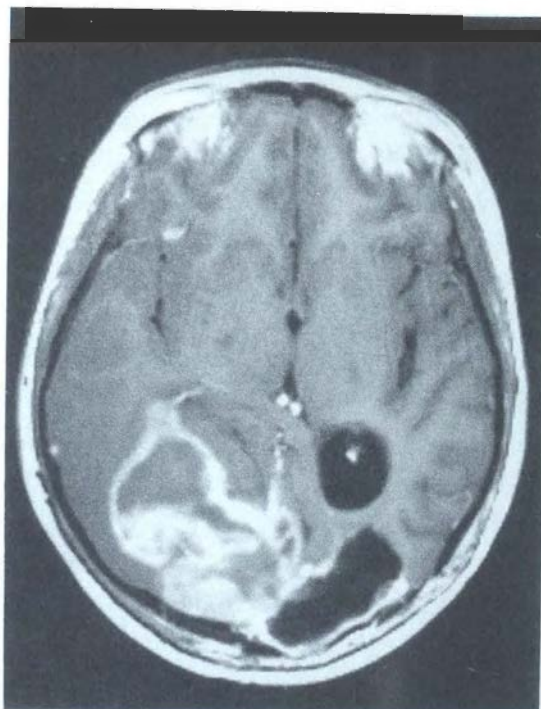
A large brain tumor showing heterogeneity of blood perfusion. A pediatric patient (11 years old), who had previously received surgery for glioblastoma multiforme, was examined for tumor recurrence 4 months after first surgery. This is a magnetic resonance image (MRI), obtained 10–20 minutes after injection of a contrast agent into the bloodstream. The region of brain from which tumor was previously excised is seen (lower right) as two dark cavities. The opposite cerebral hemisphere (lower left) has a very large invasive tumor originating from the earlier site of surgery. The tumor appears bright at the margins, where perfusion is relatively high, and dark at the core, where perfusion is relatively low. The tumor margin appears brighter than surrounding brain partially because perfusion is high, but also because contrast agent leaks across the blood-brain barrier at the tumor margin and accumulates, whereas
